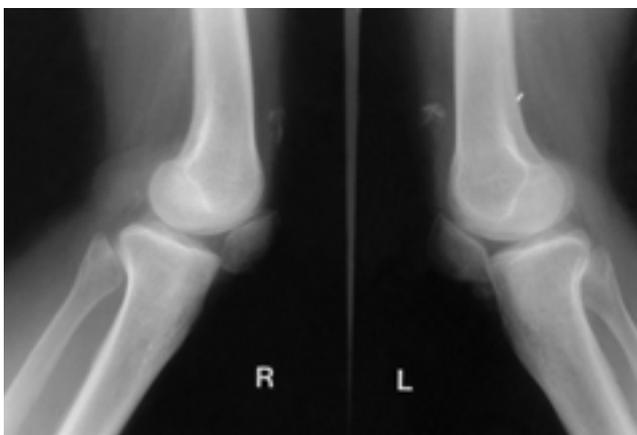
Lateral radiographs of the both knees demonstrate low lying patellae with irregular shaped calcifications in the suprapatellar soft tissues. The soft tissue planes demarcating the distal quadriceps tendons are indistinct.
